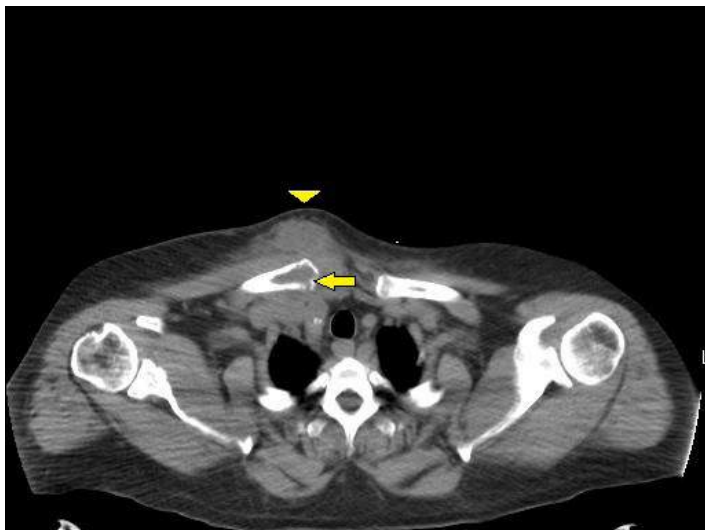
Non-contrast computed tomography of chest showing erosion of the right medial clavicle (arrow) with overlying soft tissue swelling (arrow head).
